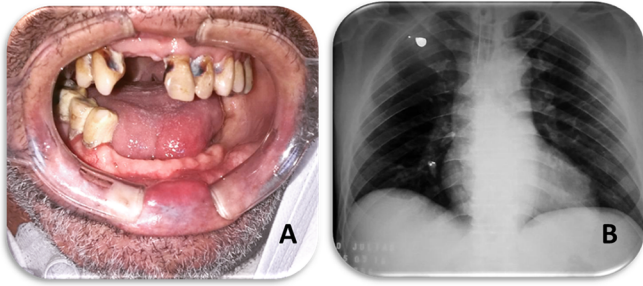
Clinical aspect and consequence of advanced periodontal disease. (A) Front view. Initial clinical evaluation showing a precarious oral condition, with a large accumulation of dental calculi and caries. (B) Posteroanterior radiograph of the thorax showing two dental elements in the right lung.
